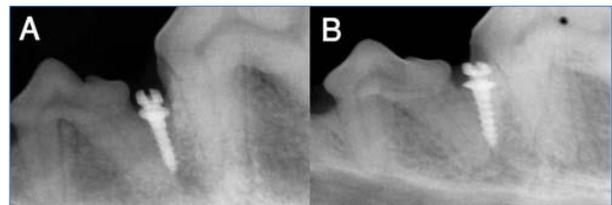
The proximity of mini-screw and root surface was confirmed by combination of two periapical x-ray with different angulations (A & B) and alteration of resistance during miniscrew insertion.
